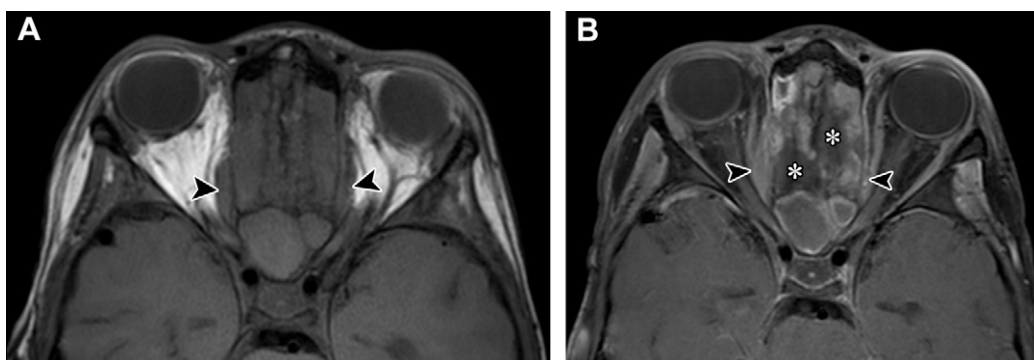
Acute invasive fungal rhinosinusitis in an 8-year-old boy with a history of orthotopic heart transplant, lymphoma, and Epstein-Barr virus infection who presented with a fever and nausea. Axial T1W (A) and contrast-enhanced T1W FS (B) MR images show extension of T1-hypointense, enhancing tissue through the lamina papyracea into the medial orbits (arrowheads). The postcontrast image shows the “black turbinate” sign (*), nonenhancing necrotic tissue from fungal invasion.
